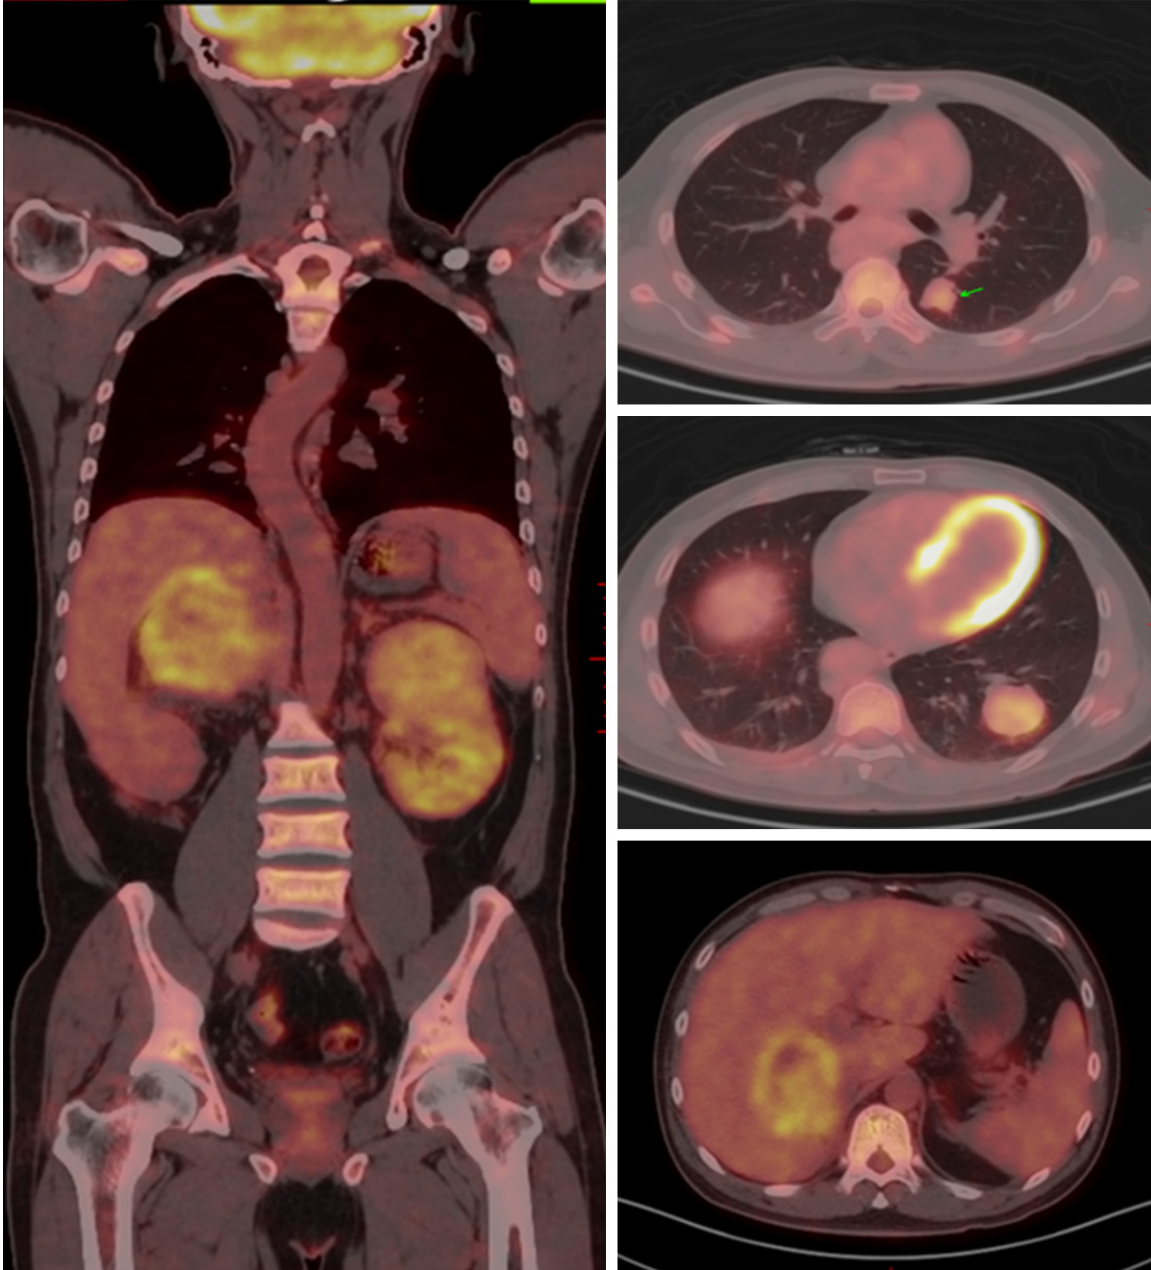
The PET-CT examination demonstrated two huge solid mass with accumulated ^{18}F FDG uptake in the middle-upper left kidney and above the right renal region respectively, accompanied with some enlarged lesions in the lung and the liver.
